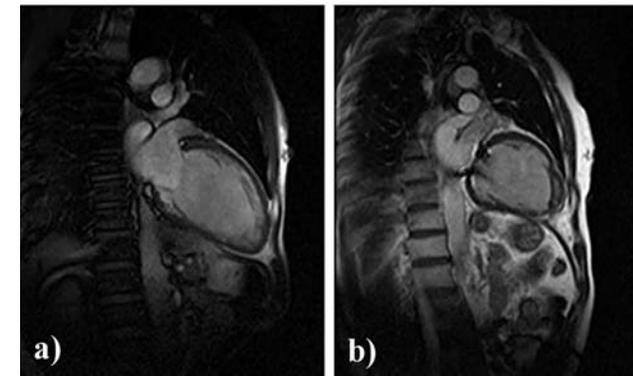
MRI image of LV in early systole; a) before, b) after TR3ISVR™ procedure (from Silesian Center for Heart Diseases).
